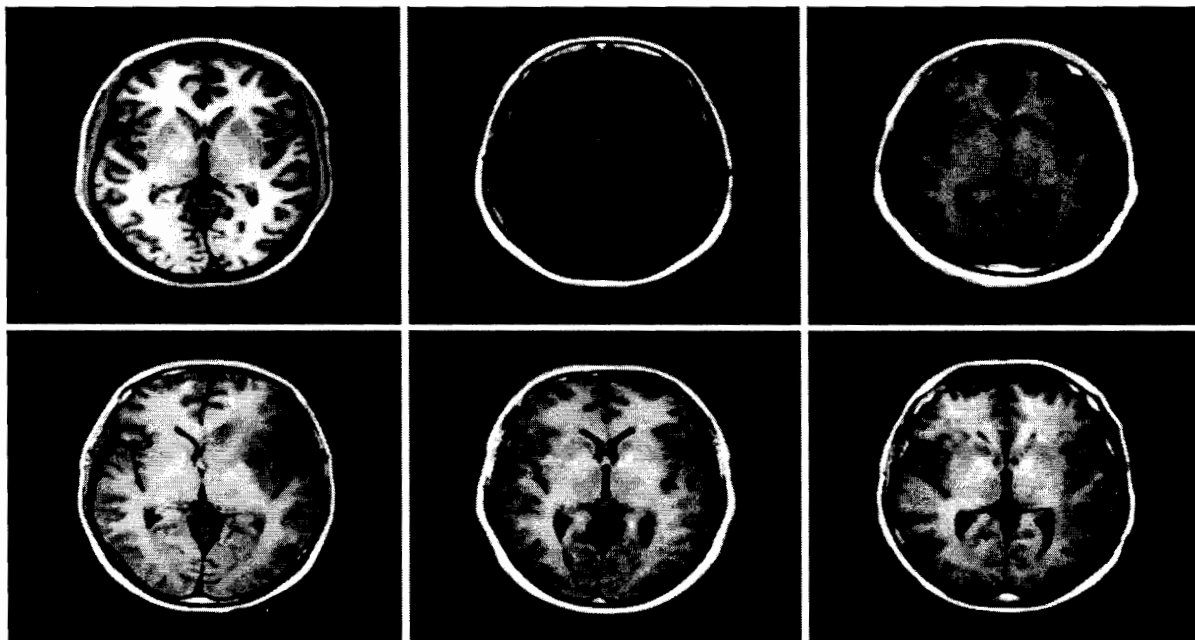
3-D Magnetic resonance images template registration.
